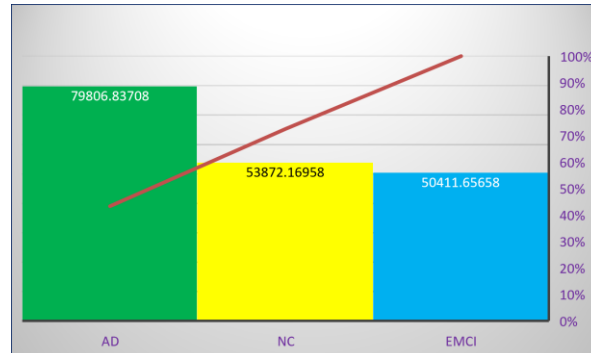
Pareto chart of MSE feature analysis for MRI slices of the female subject
